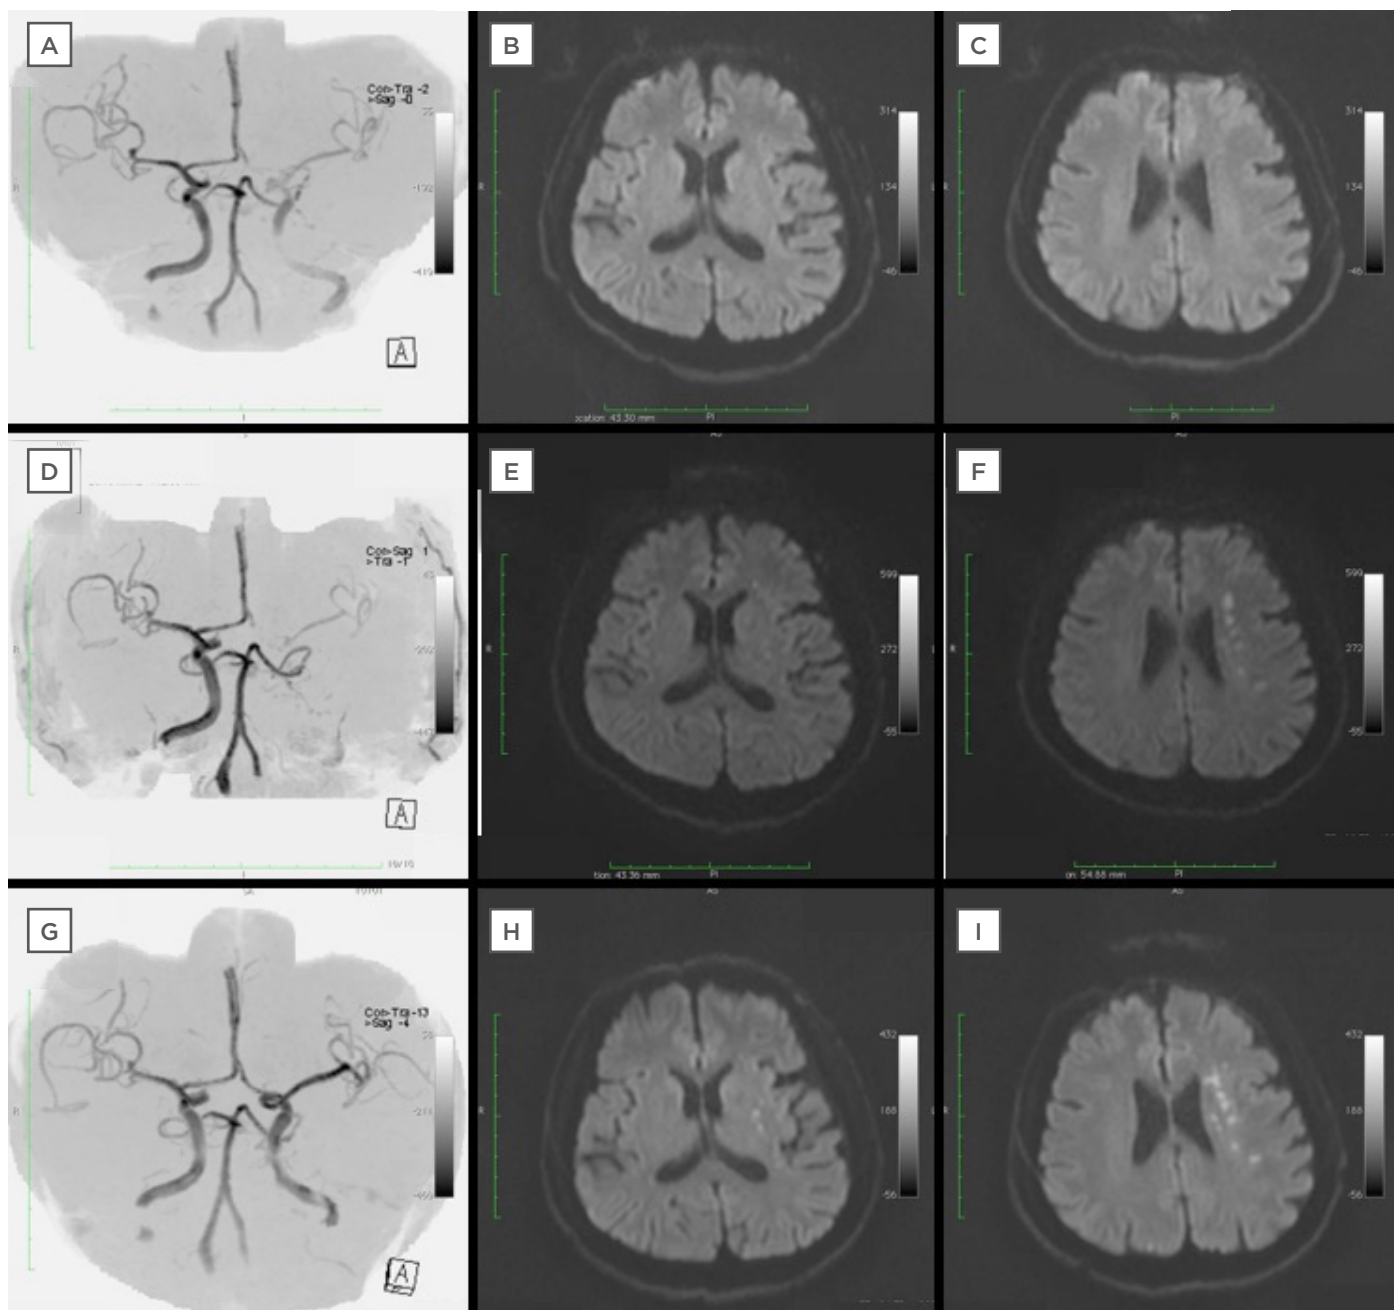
Magnetic resonance imaging of a 63-year-old man admitted with a National Institutes of Health Stroke Scale Score of 7.
